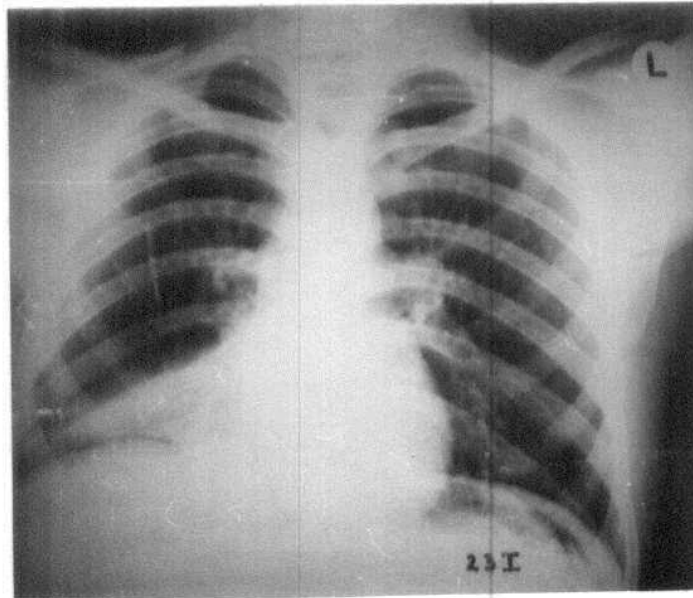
Postoperative chest radiograph for patient No. 23 I (24 hours after surgery): showing right basal patch of consolidation-collapse. Postoperative pneumoperitoneum is seen under elevated right coupla.
